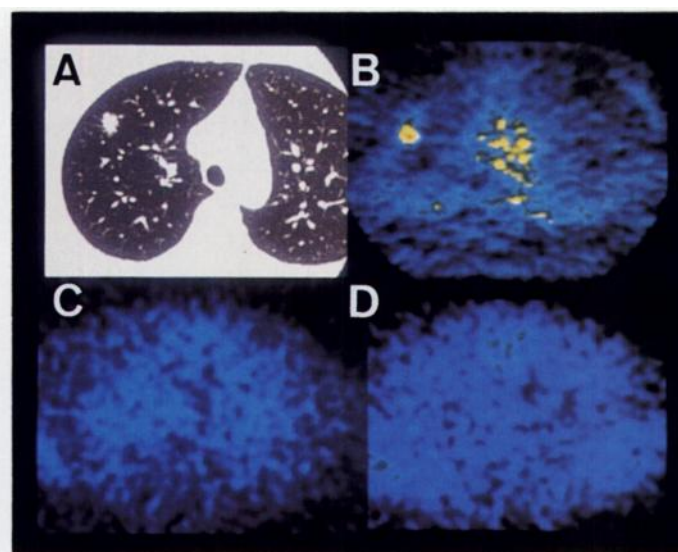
Patient 12, moderately differentiated tubular adenocarcinoma, 1.5 × 1.5 × 1.2 cm, pT1N0M0. (A) CT image shows nodule in the right lung. (B) FDG PET shows hot accumulation in the tumor (SUV, 2.64; T-to-N ratio, 3.59). (C) Early scan on Tl SPECT. (D) Delayed scan on Tl SPECT. Neither early nor delayed Tl SPECT visualized any lesions.
